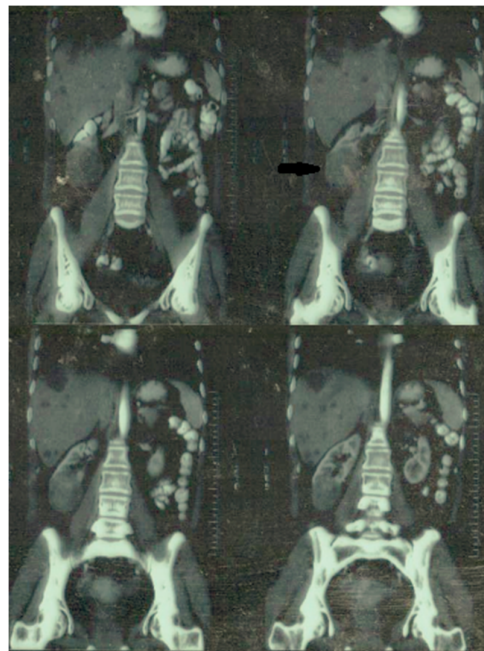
CT scan indicating multiple liver cysts and a mass in the lower pole of right kidney (black arrow). Biopsy of one of the liver cysts was negative for malignancy. Nephrectomy showed metastatic PTC in the kidney.
